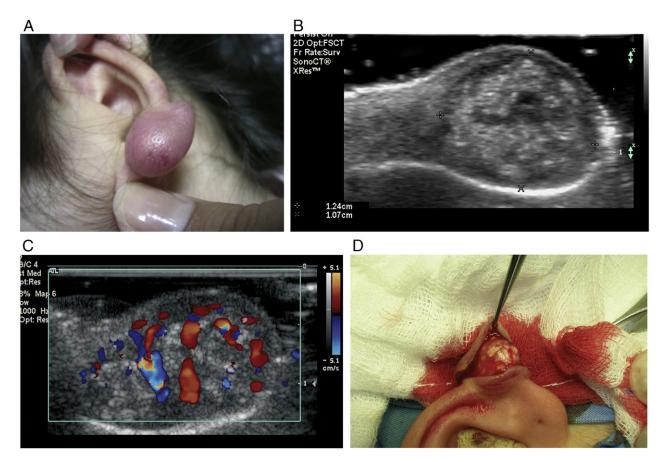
Case 1. A, Erythematous swelling in the lobule of the left auricle. B, Ultrasound (longitudinal view): nodule with hypoechoic rim and hyperechoic center containing hyperechoic dots suggestive of calcium deposits. C, Color Doppler ultrasound (longitudinal view): increased blood flow within and around the nodule. D, The tumor at surgery.
